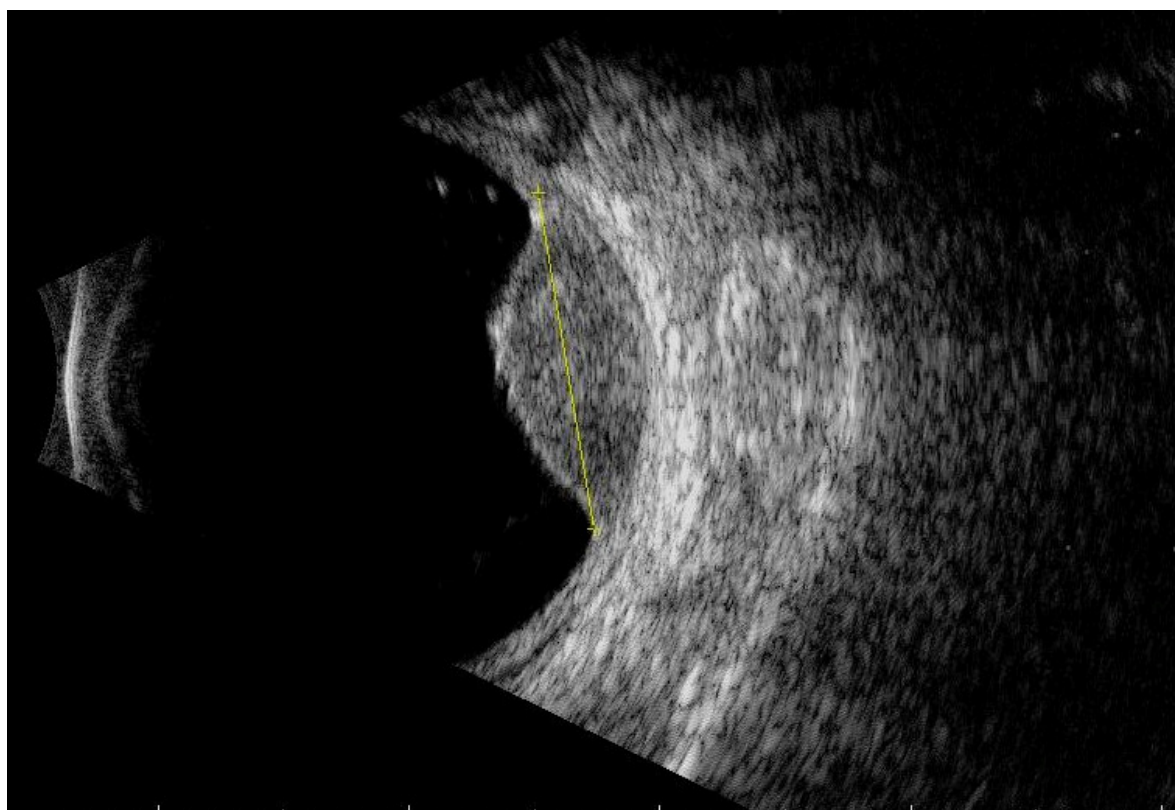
B-scan ultrasound of the tumor in Figure 2E eight months after cataract surgery. The tumor's apical height has decreased further to 5.6 mm.
